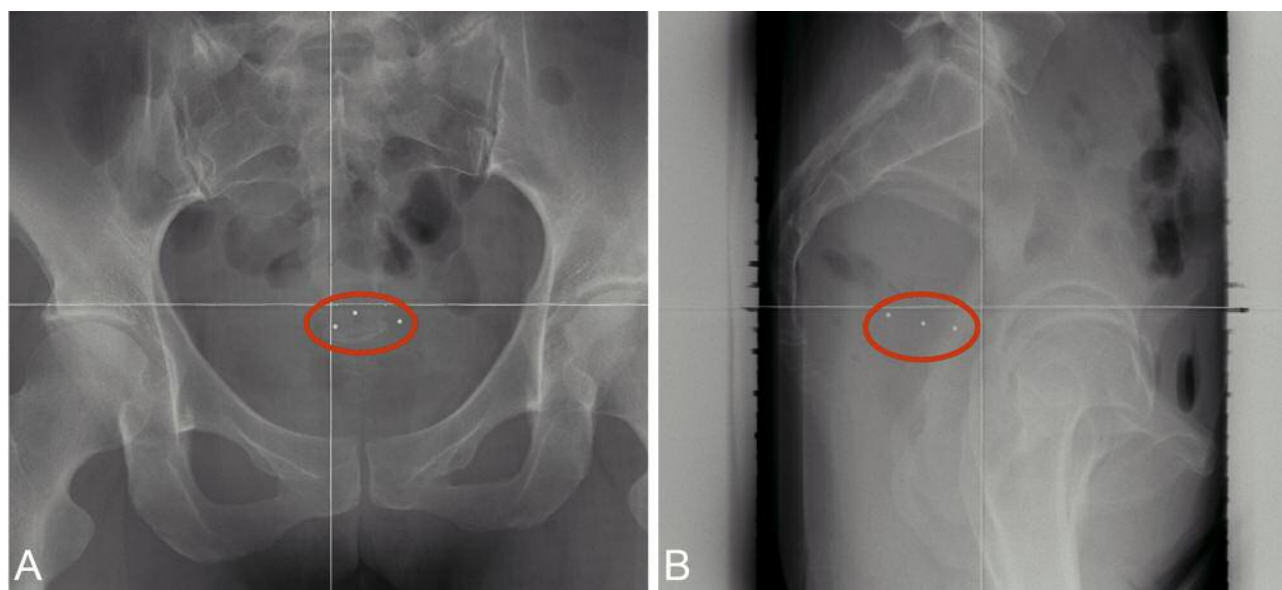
Orthogonal X-ray images of a patient with insertion of the device. A: Vertical image. B: Horizontal image. Red circles show the tungsten markers.
